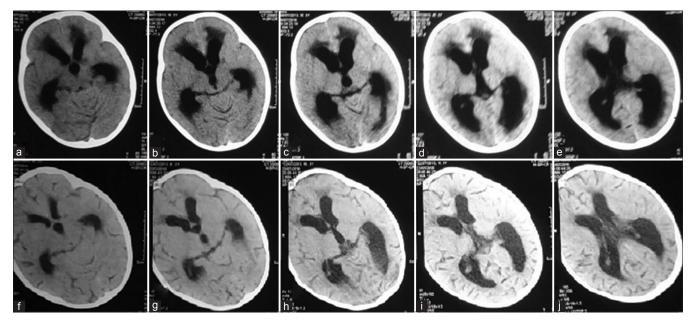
Preoperative (a-e) and postoperative (f-j) computed tomography scans showing resolution of hydrocephalus following endoscopic third ventriculostomy
